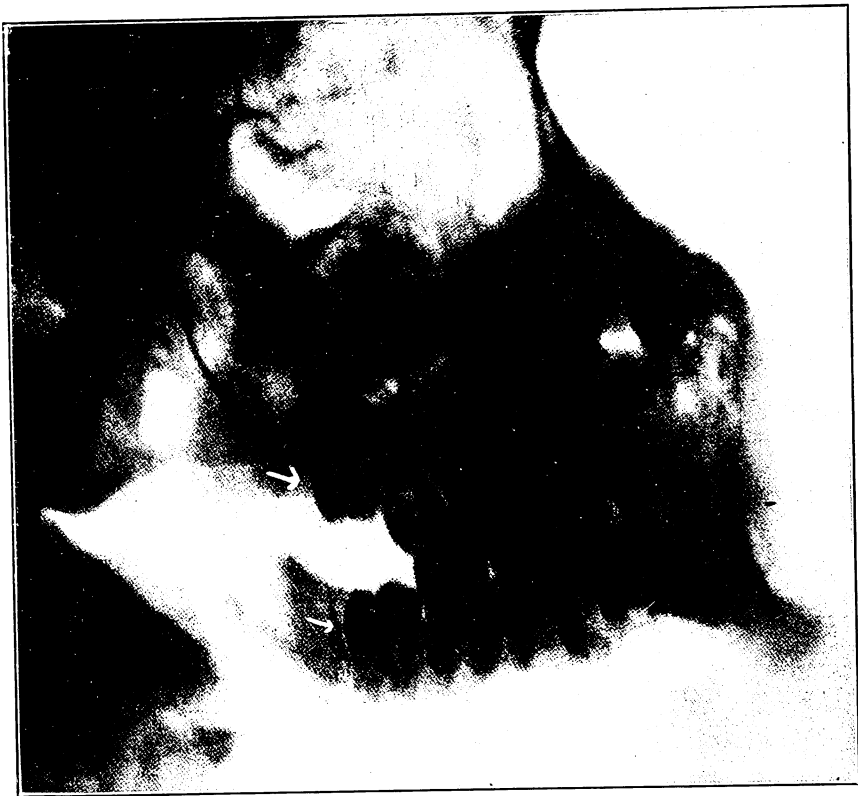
Radiograph made from the pose shown in Fig. 102. The arrows point to unerupted upper and lower third molars.
